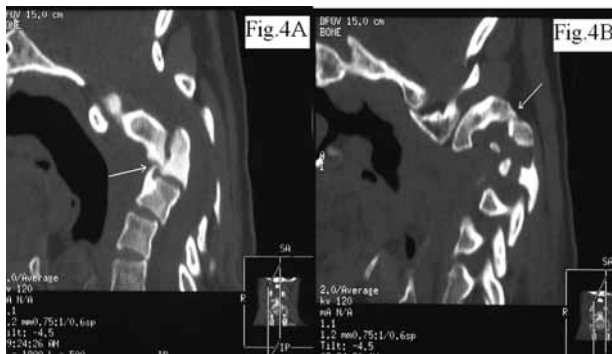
CT scans of the neck, sagittal sections in different planes at the end of 1 year. Section (a) shows an ossified bridge of bone between the anteroinferior tip of C2 and superior endplate of C5 (white arrow). b) is a slice through the facet joints showing fusion between the C2 and C3 facet joint. This fusion prevented C2/3 subluxation despite the gross rotation of the C2 vertebral body and hence the canal dimensions were maintained.
